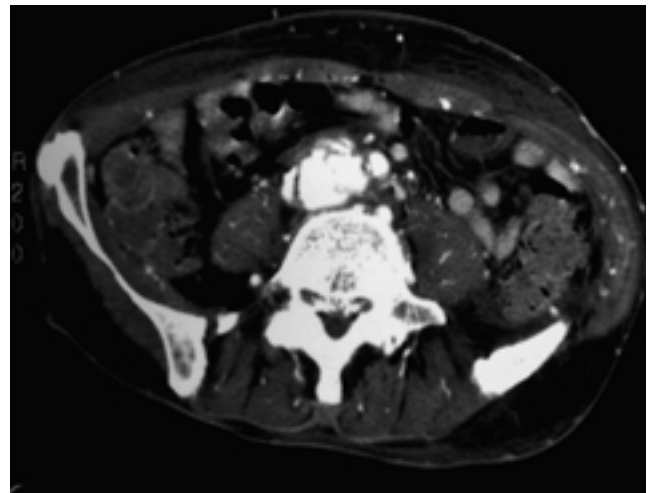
Arterial phase CT scan shows simultaneous contrast enhancement of aorta and dilated inferior vena cava.
